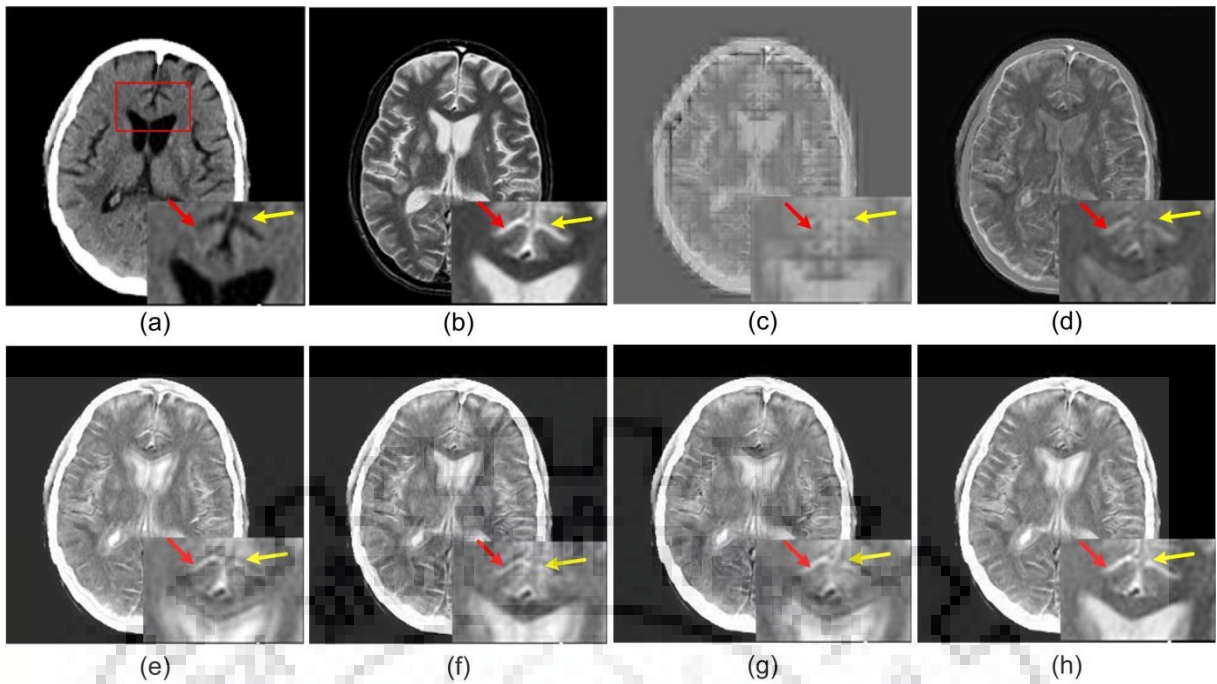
Comparison between visual performance evaluated by the fusion approaches for set-2 of (a) CT image and (b) MR image, using (c) Method 1 (d) Method 2 (e) Method 3 (f) Method 4 (g) Method 5 (h) Proposed C-MIF approach
